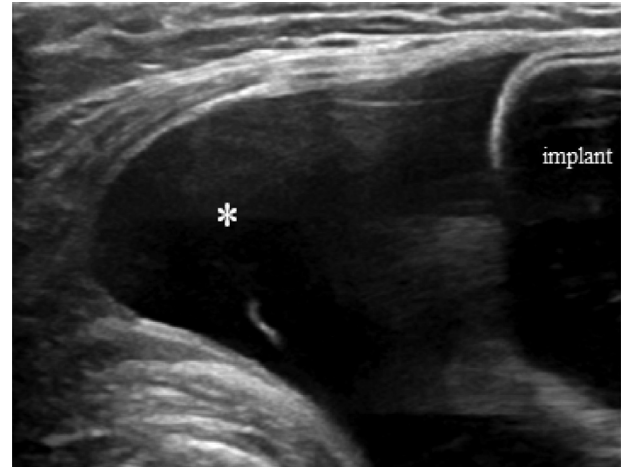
Targeted ultrasound of the right breast demonstrates a large fluid collection (asterisk) surrounding the breast implant.
